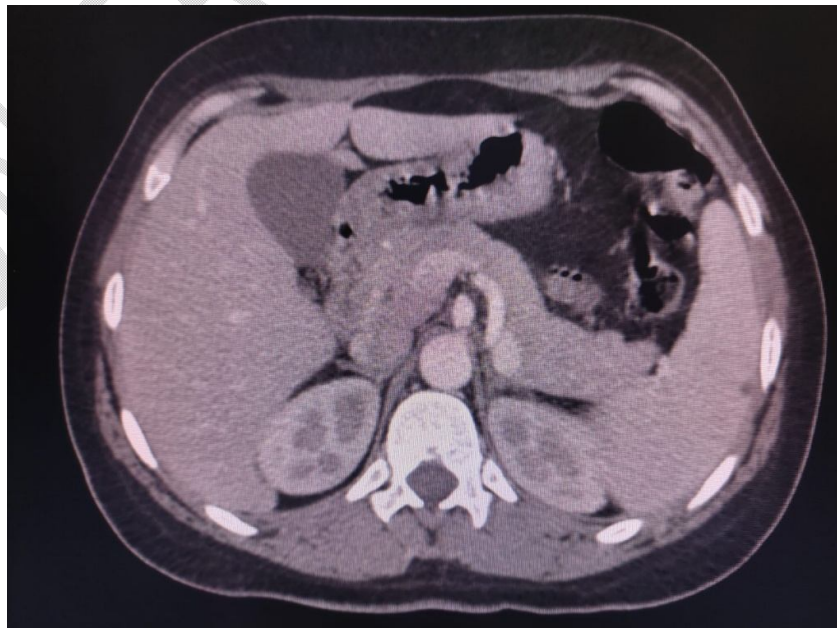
axial slice MRI showing a normal pancreas
